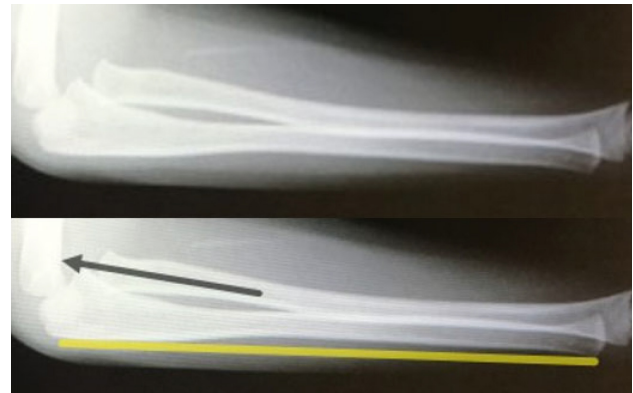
Forearm radiographs two weeks after trauma. In the upper image we see the radiograph itself, and in the lower one, the arrow indicates the presence of dislocation of the radial head, and the line shows the ulna bowing.
